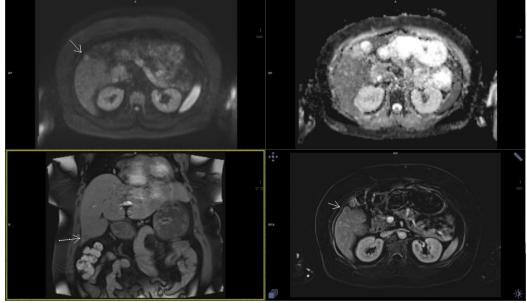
MRI examination of the abdomen. The white arrow is pointing to a metastasis.
